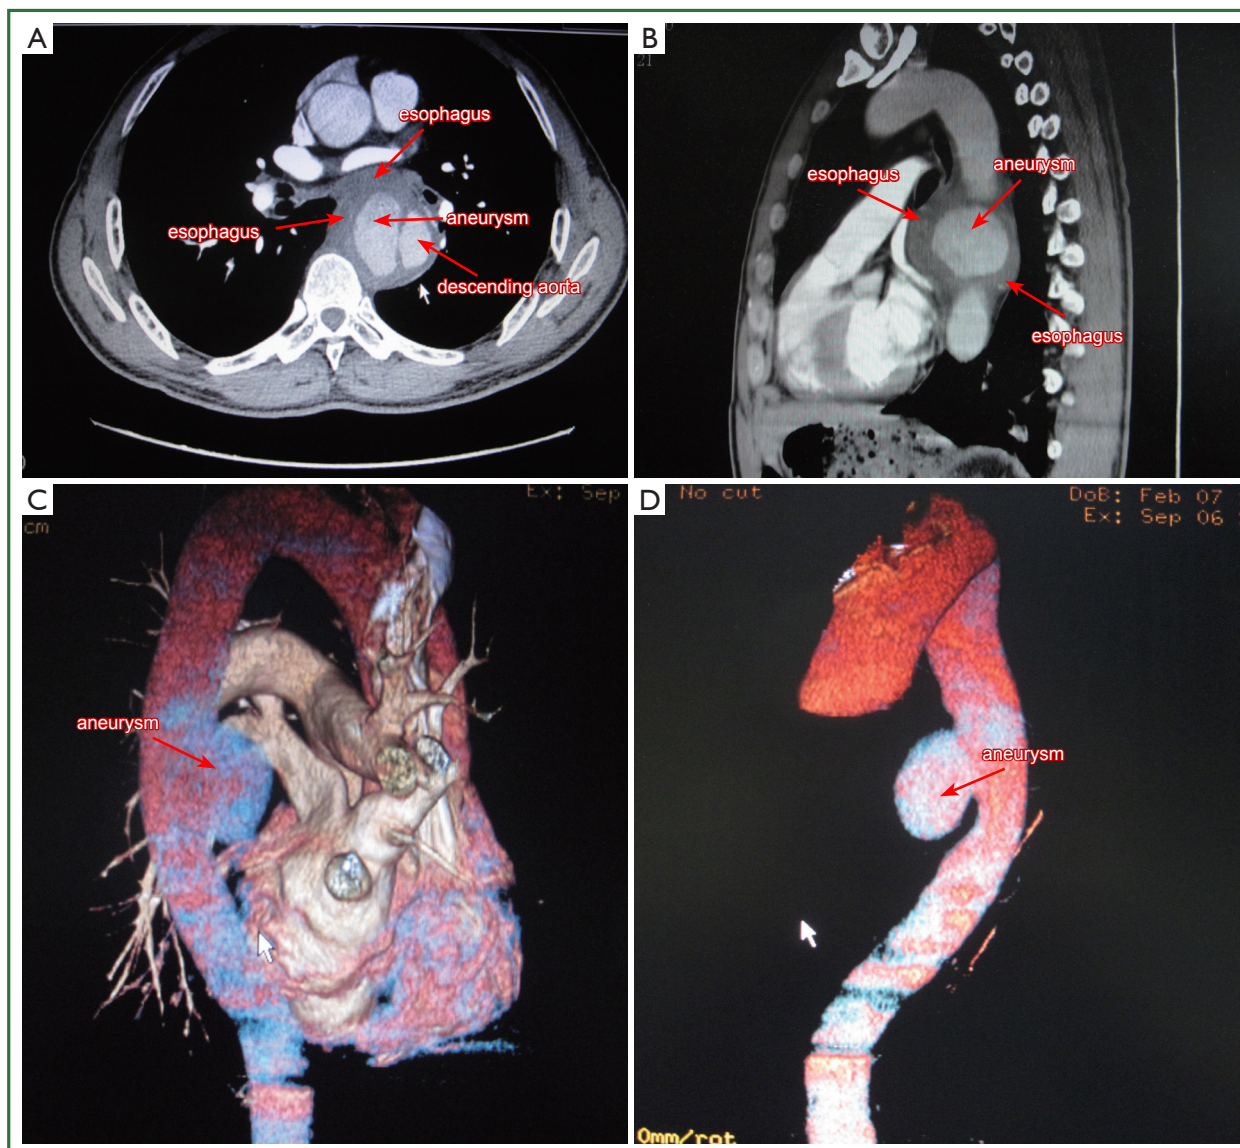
(A,B) The chest contrast computer tomography (CT) scan showed a descending aorta aneurysm with moderate compression into the adjacent esophagus; (C,D) The 128-slice computer tomography (CT) angiography showed a three-dimensional aneurysm arising from descending aorta, extending to the right posterior direction.
